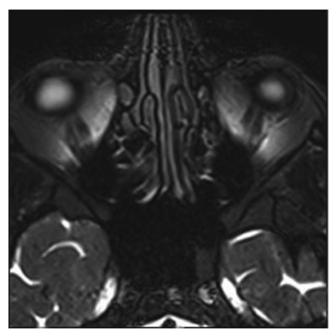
Axial T2-W1. Transverse section of the orbit showing normal optic nerve without ONT preflight; not an intra-astronaut pre- to postflight comparison. MRI image provided by the Lifetime Surveillance of Astronaut Health (LSAH) Program, NASA Johnson Space Center.
